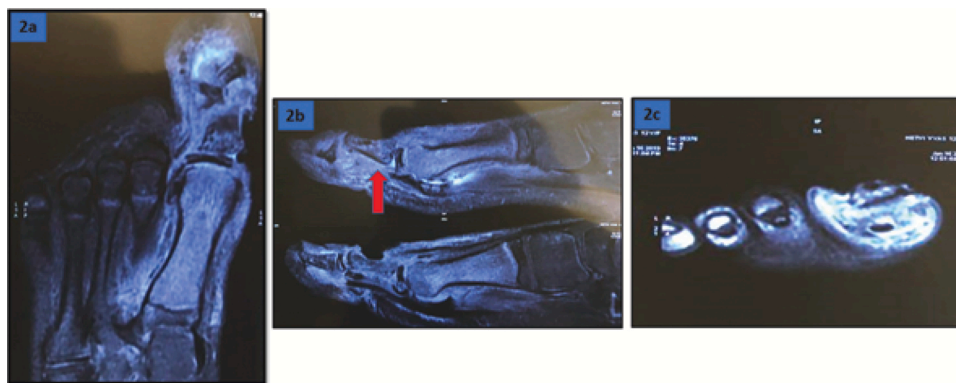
a–c: Various sections of MRI left foot showing dorsal skin defect, soft tissue and bone marrow edema with necrotic proximal phalanx. Physeal separation of proximal phalanx (red arrow) with dislocation of the pip joint is clearly evident on the sagittal sections.
